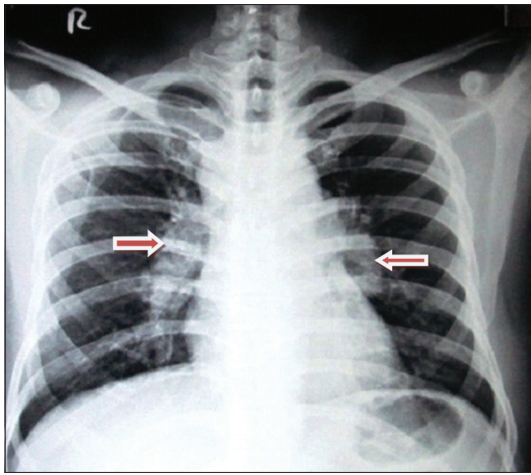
Chest X-ray showing bilateral hilar adenopathy (arrows)
